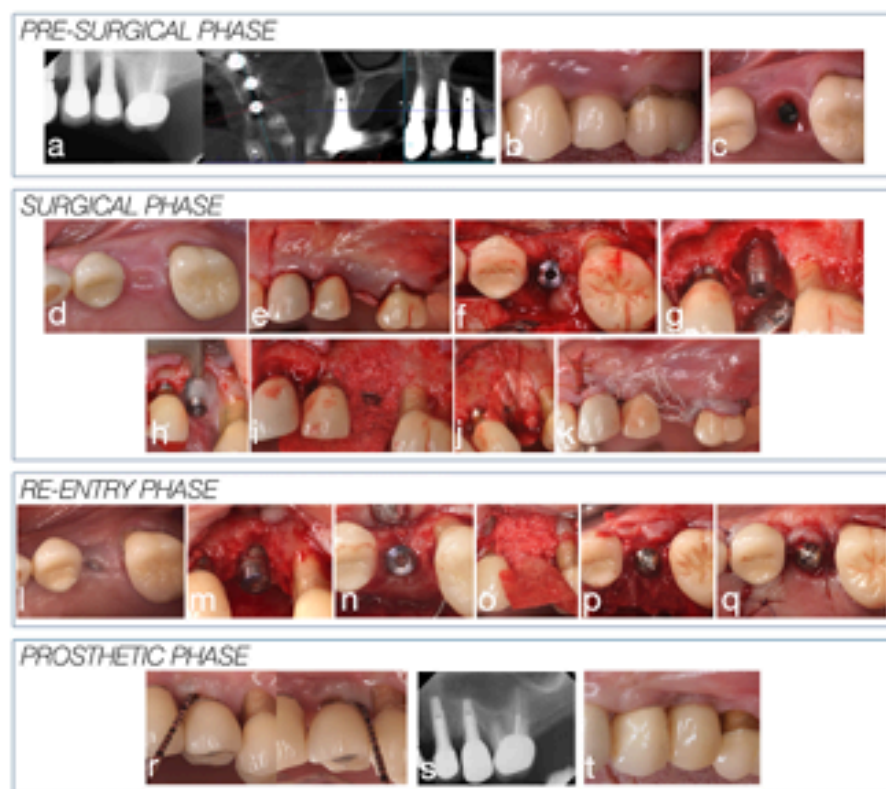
Clinical case – Defect Ic. a) Baseline periapical radiograph, CBCT scan, and b) clinical image of an implant affected by peri-implantitis in the position of the left maxillary second premolar. c) Removal of the prosthetic crown and placement of the cover screw prior to non-surgical therapy. d) Eight-week healing of the soft tissues completely covering the cover screw following non-surgical therapy. e) Mid-crestal incision with mesial and distal vertical releasing incisions; f) flap elevation and occlusal visualization of the non-degranulated peri-implant defect; g) vestibular view of the degranulated defect; h) decontamination of the implant surface using erythritol-based air polishing; i,j) placement of the bone graft and collagen membrane stabilized with periosteal sutures using the "LASSO" technique; k) flap suturing. l) Clinical image at 6 months after the first surgical phase; m,n) vestibular and occlusal visualization of the residual intrabony defect; o,p) placement of the bone graft and collagen membrane fixed with the healing abutment using the "poncho-like" technique; q) flap suturing. r) clinical images with the baseline prosthesis showing probing depths compatible with health; s,t) radiographic and clinical images showing
